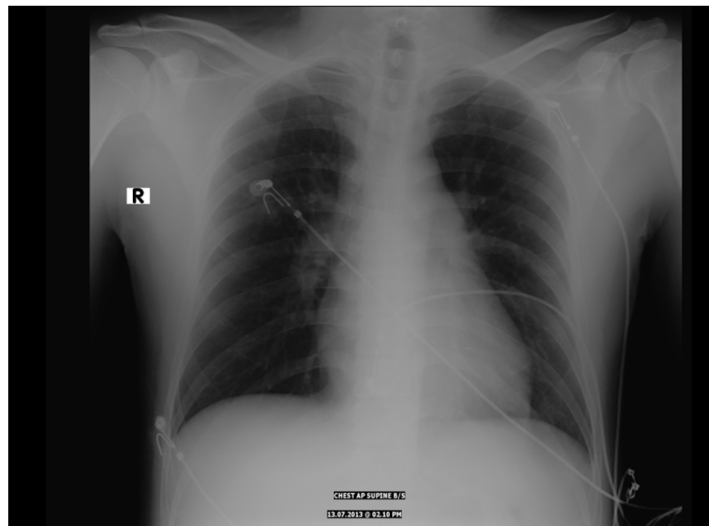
Chest radiograph showing abrupt cut-off of the right descending pulmonary artery with oligemia in the right lower zone of the right lung.
